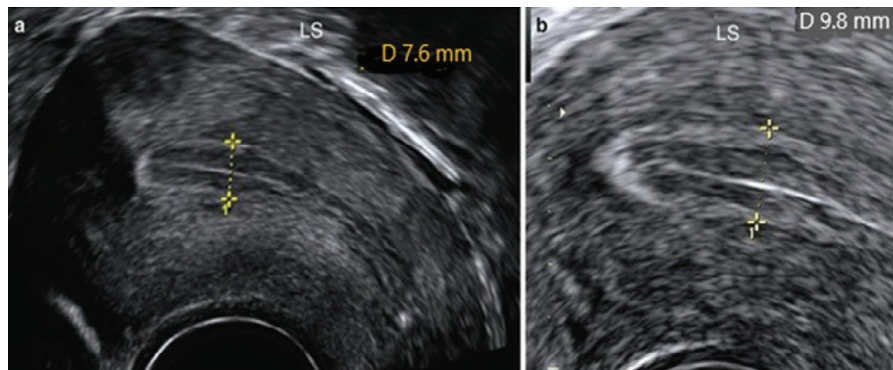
Ultrasound of Endometrial thickness (a woman 20 years old; the 5th day of the menstrual cycle)
